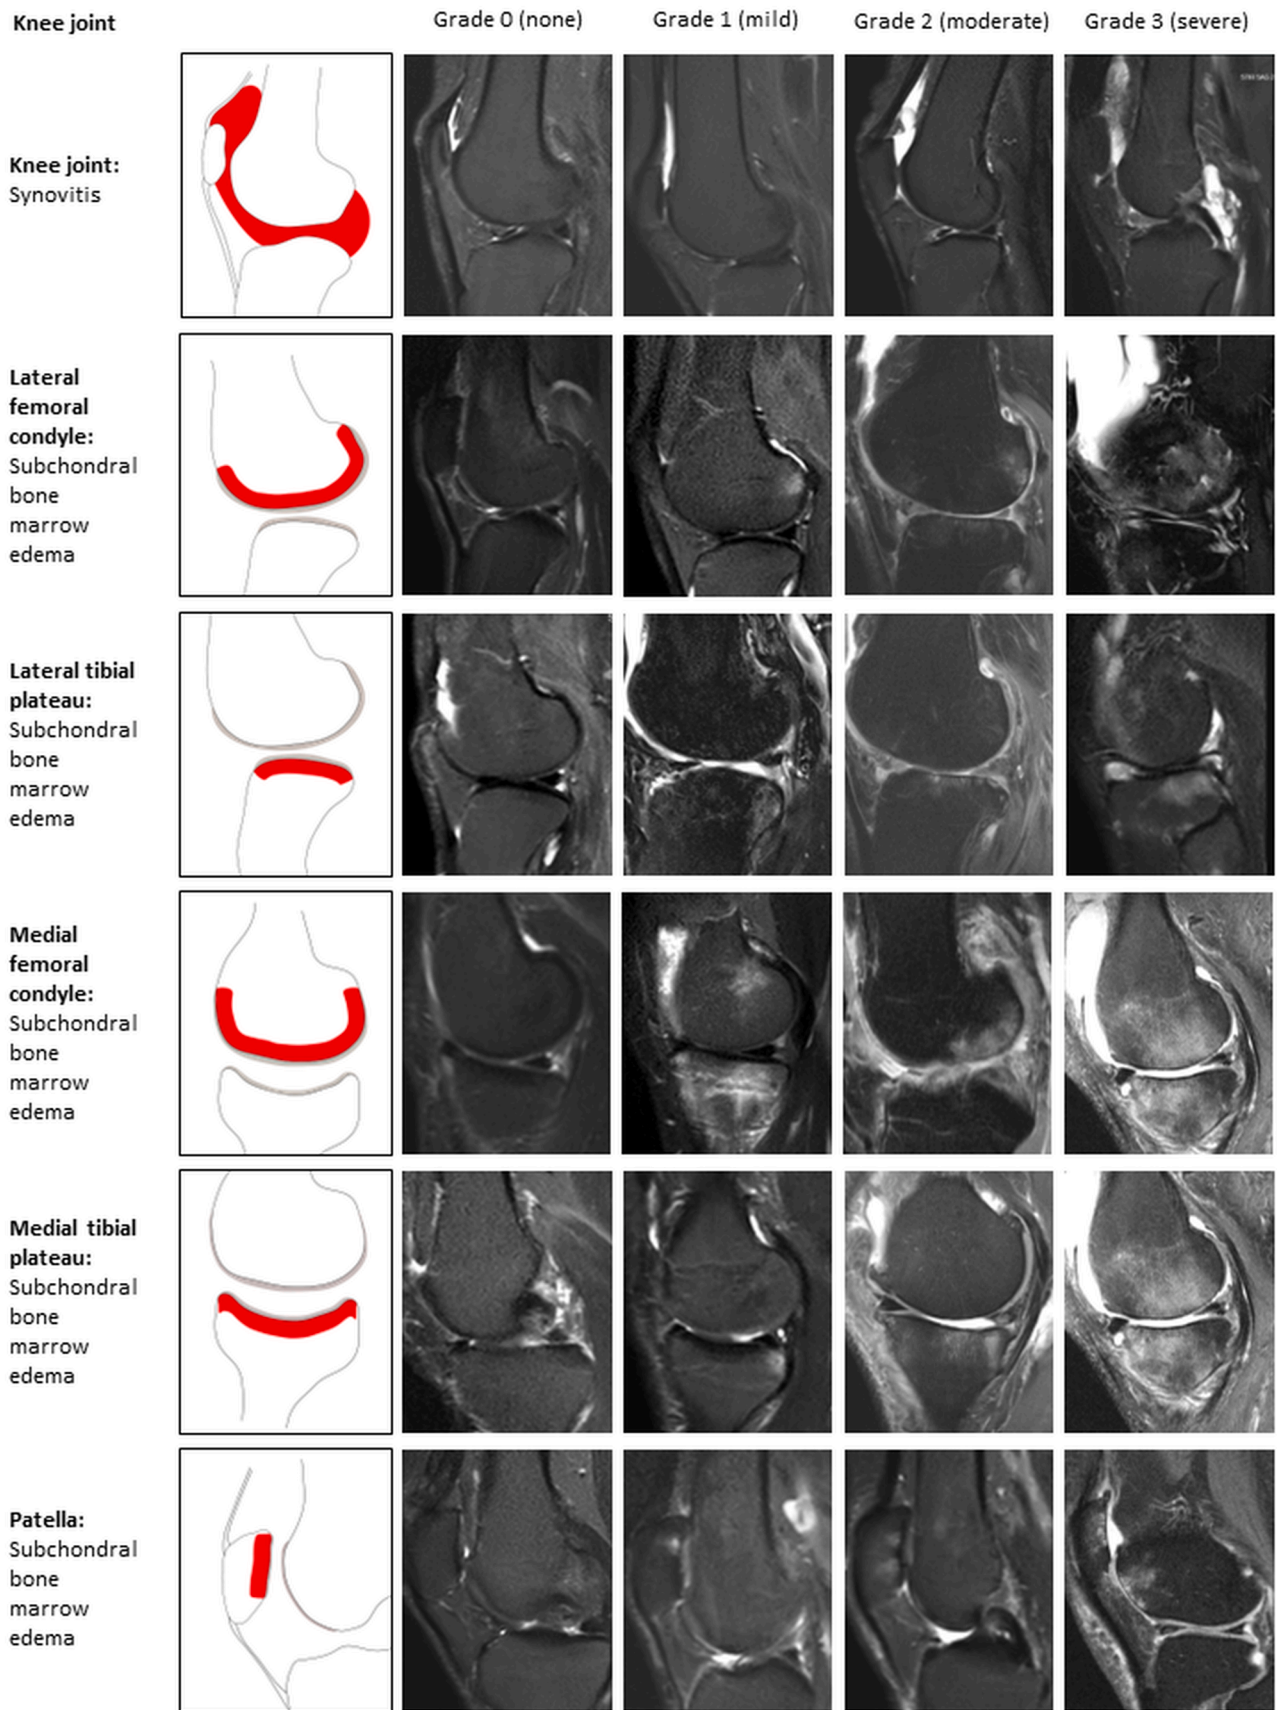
MRI-WIPE scoring system grades for knee joint inflammatory pathologies.
